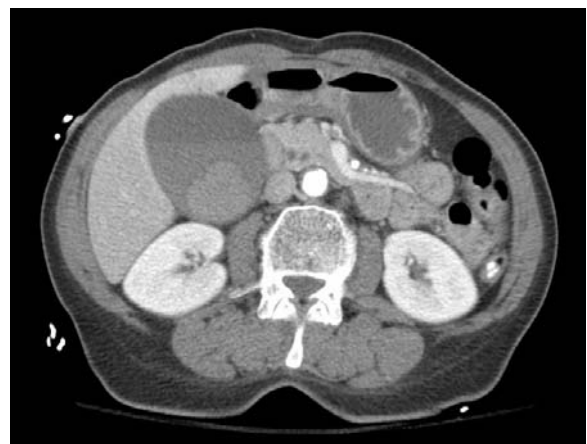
Hemorrhagic acalculous cholecystitis imaged by CT scan. Clot (solid matter) and unclotted blood (fluid density within the bile) is visible within the lumen of a markedly distended gallbladder
